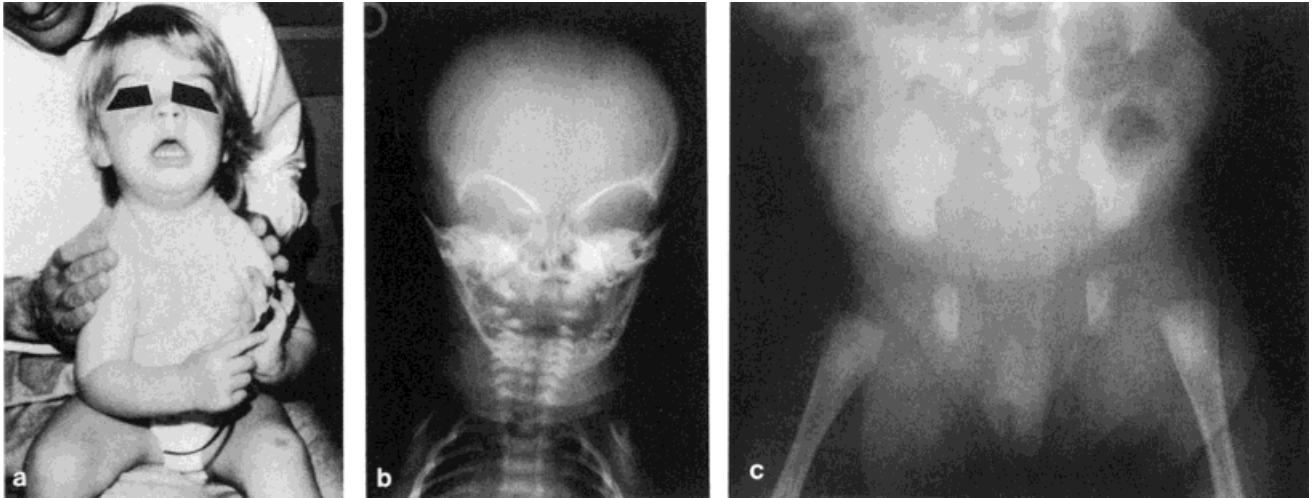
a: Patient 1 at age 2-1/2 years. b: AP skull and chest radiograph. Note the severely hypoplastic clavicles. c: Radiograph showing absent ossification of the pelvic bones.
